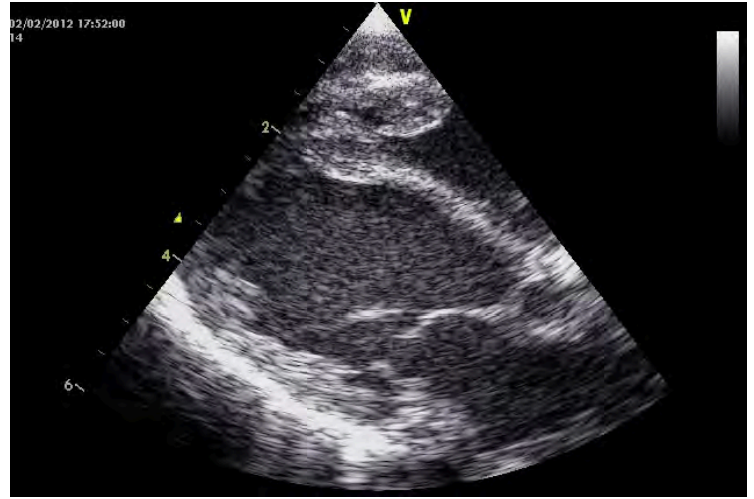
Echocardiography on the morning after conversion to sinus rhythm. Parasternal view showing a dilated left ventricle, left ventricle internal diameter of 24 mm.
